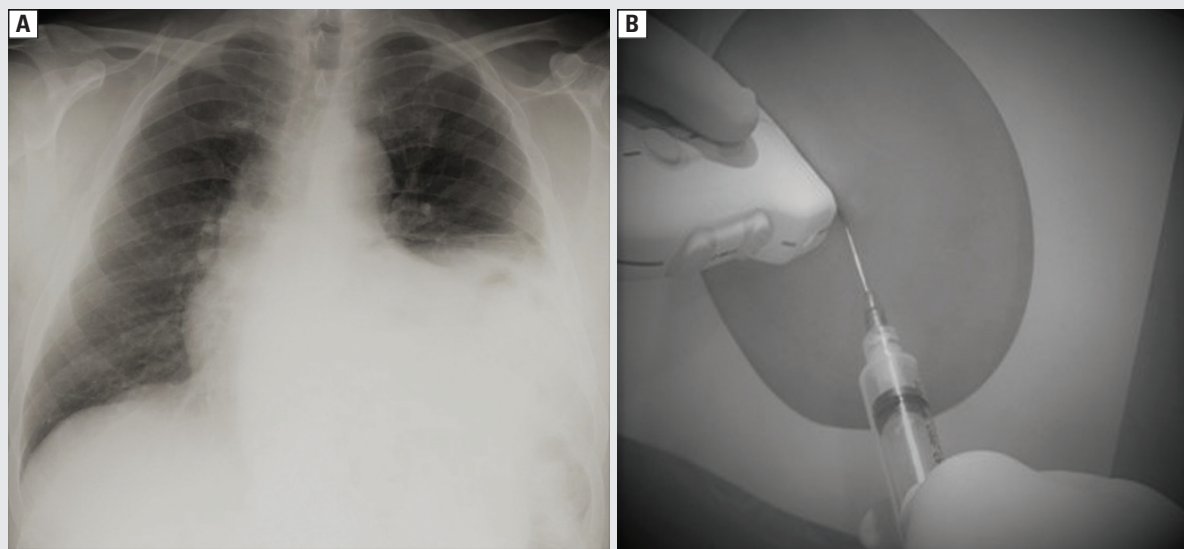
A. Chest X-ray; B. Ultrasound-guided thoracentesis
